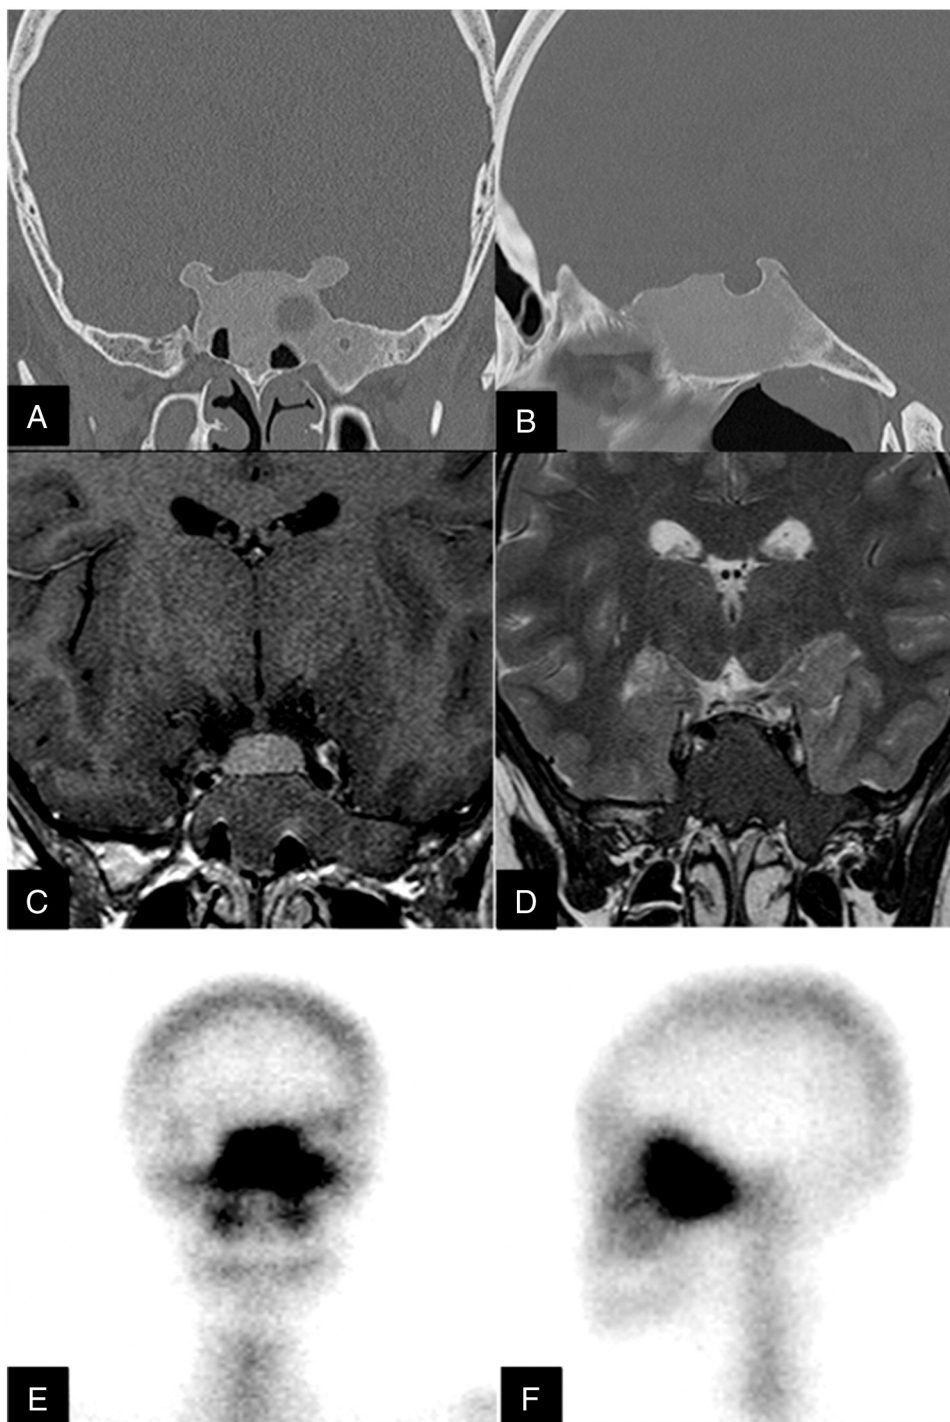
(A–F) Fibrous dysplasia involving S corpus and left greater wing with ground glass appearance at coronal and sagittal planes from bone windows on CT (1A–B); hypointense signals with T1-weighted without contrast and T2-weighted coronal images on MRI due to fibrous and bone tissue (1C–D); overt radioactive media on the scintigraphic examination (1E–F).
